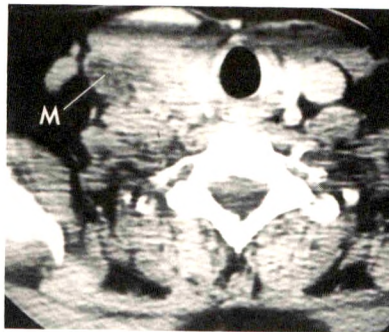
62-year-old man with squamous cell carcinoma. CT scan shows mass (M) with central lucency, characteristic of metastases to lymph nodes with central necrosis.
